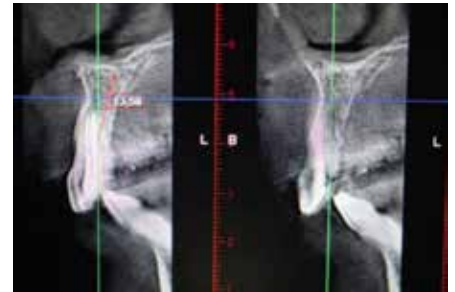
Radiograph pre-treatment.
